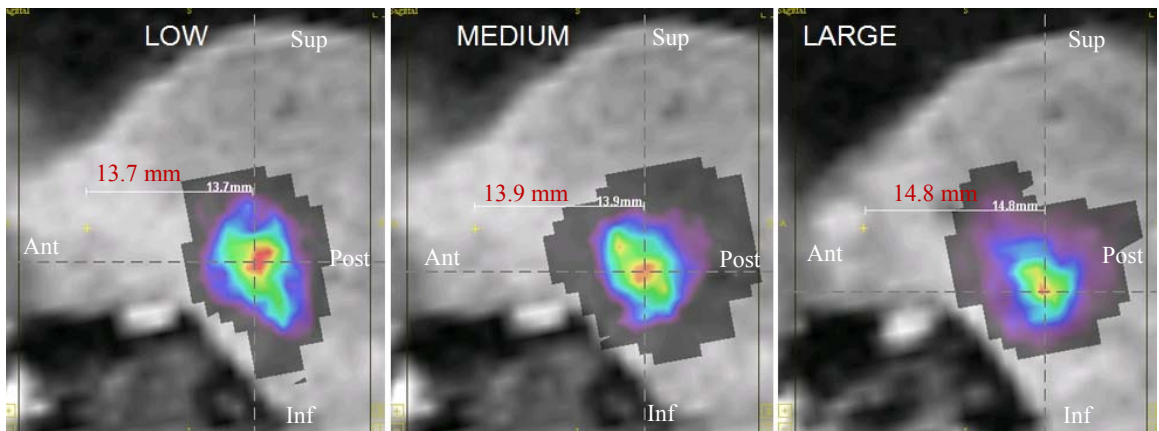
Low-, medium- and large-shift PD efficacy maps for the left brain overlaid on the MRI atlas shown in (a) axial, (b) coronal and (c) sagittal orientations.
